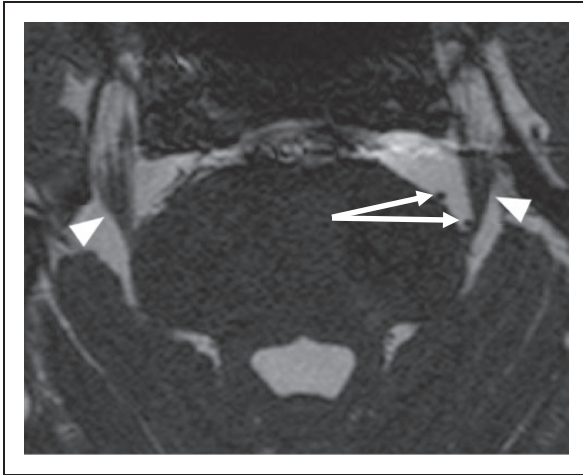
MRI in a patient with left-sided classical trigeminal neuralgia. Balanced fast field echo sequence of the fossa posterior, axial plane, at the level of the pons. The left trigeminal nerve (right-sided arrowhead) is displaced by an arterial loop (arrows) from the anterior inferior cerebellar artery.
